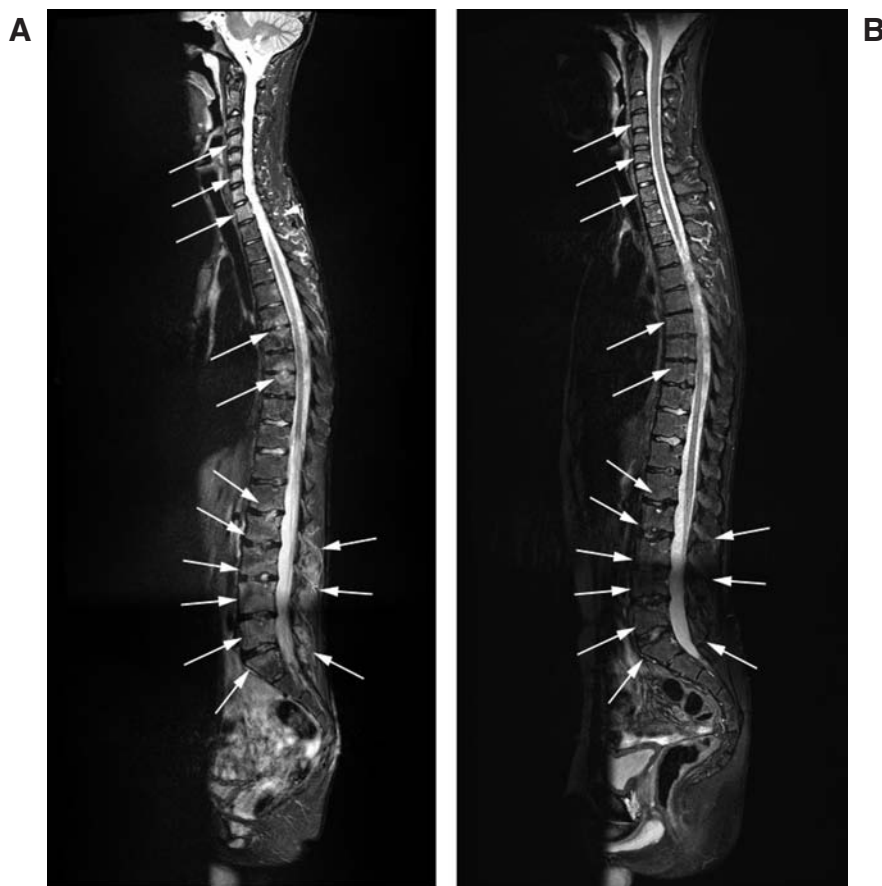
A. Whole-body MRI before therapy detected extensive erosive inflammatory spondylitis in segments C5–T1, T6/T7, T8/T9, and L1–L5 and acute inflammation of various facet joints in the lumbar spine (arrows).
